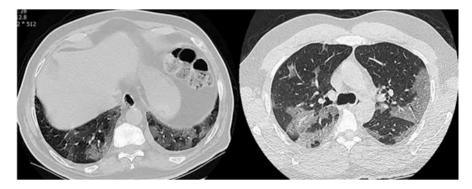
Two axial chest CT scans without contrast show multifocal subpleural patchy groundglass opacities (GGOs) with interlobular septal thickening (crazy-paving) in lower lobes of both lungs in a patient with COVID-19 pneumonitis
